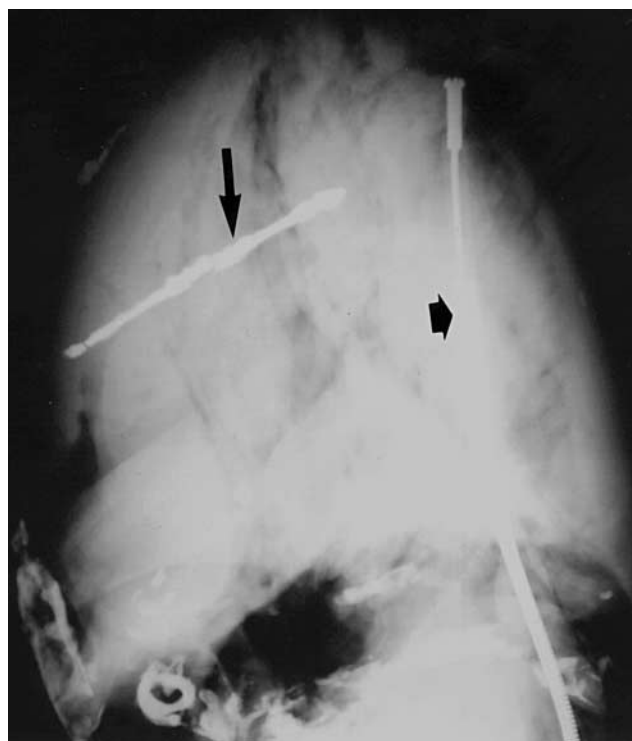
Post-mortem X-ray of heart demonstrates the foreign body (long arrow) and the pacing wire (short arrow)
